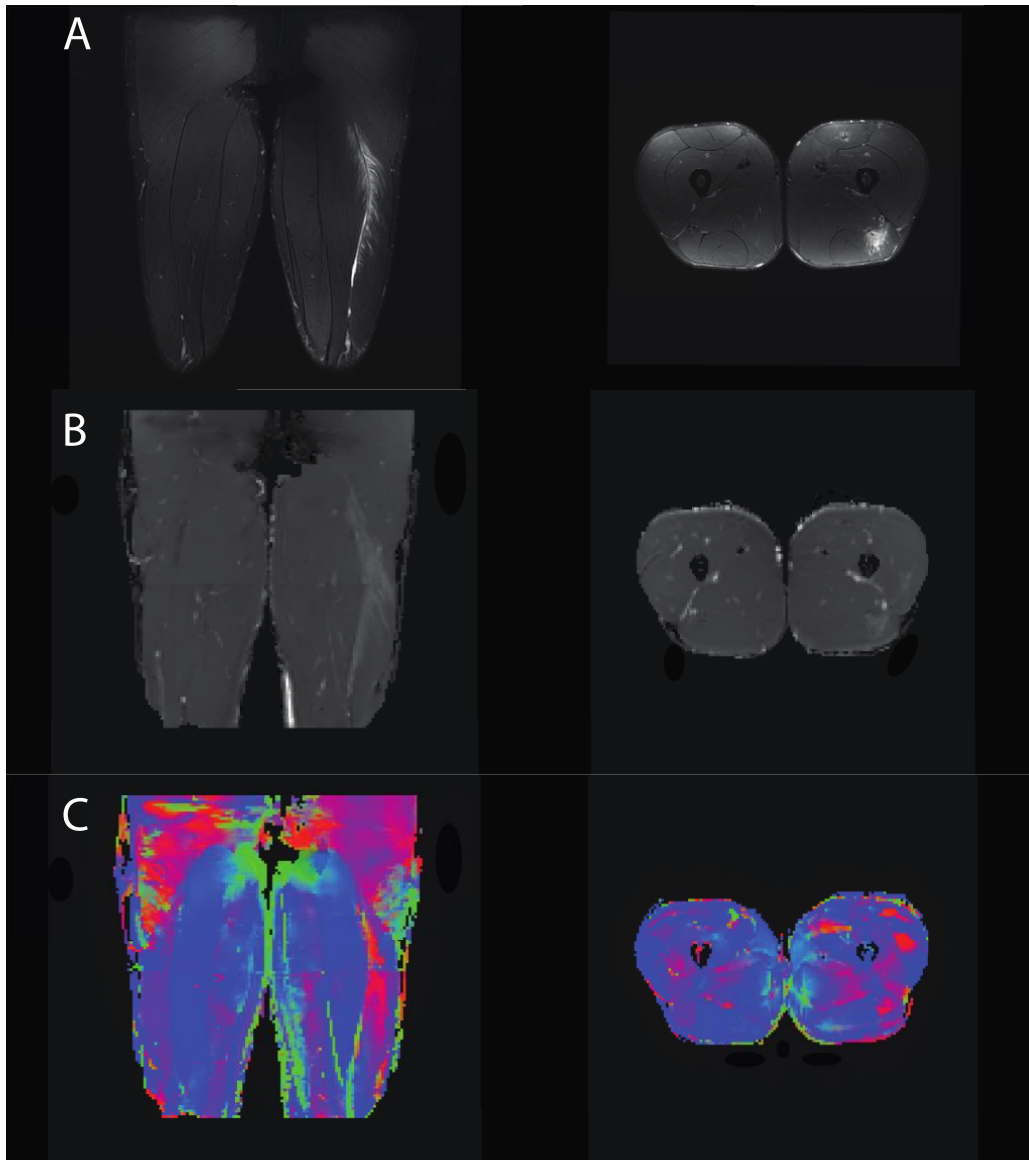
Representative imaging data from one participant at time of injury, A.) T2-weighted, B.) mean diffusivity, and C.) primary eigenvalue maps along principal direction (λ_1).
